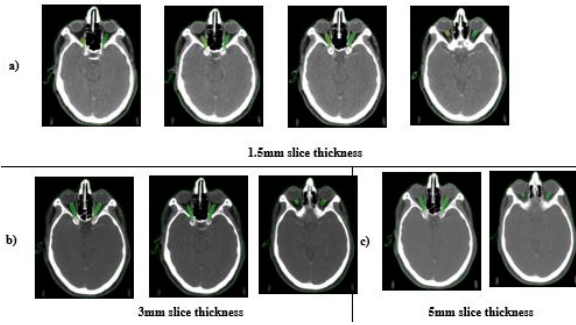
Contour of optic nerve in different CT slice thickness.
